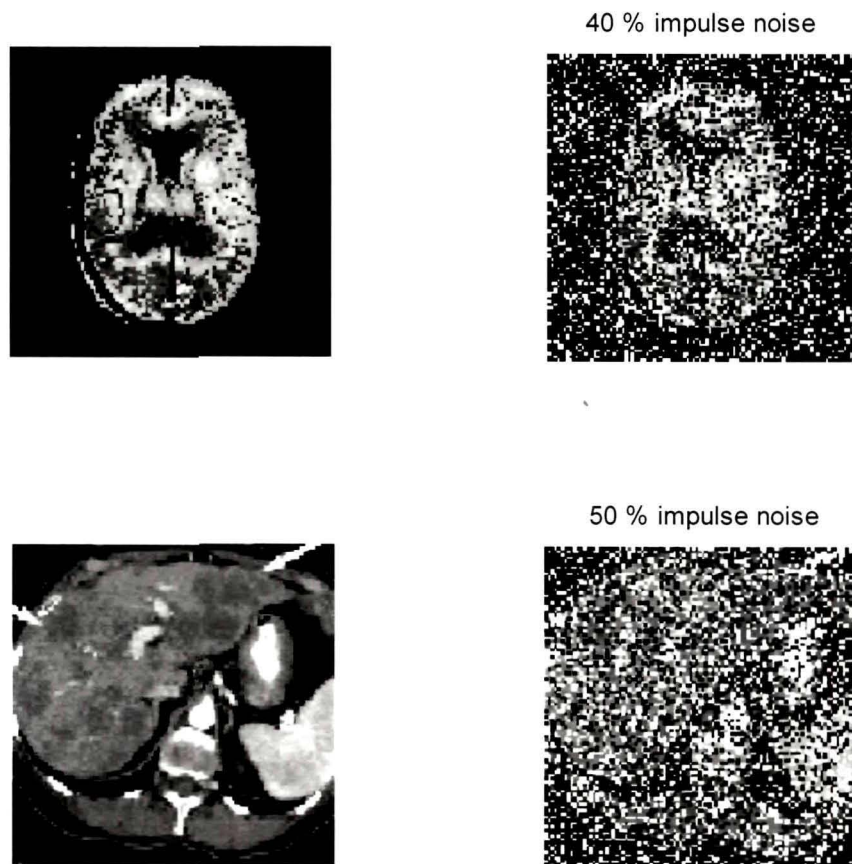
(a) some of the SPECT images that formed the part of the training / testing database, (b) their noisy images with densities of 10%, 20%, 30% 40% and 50% respectively.
